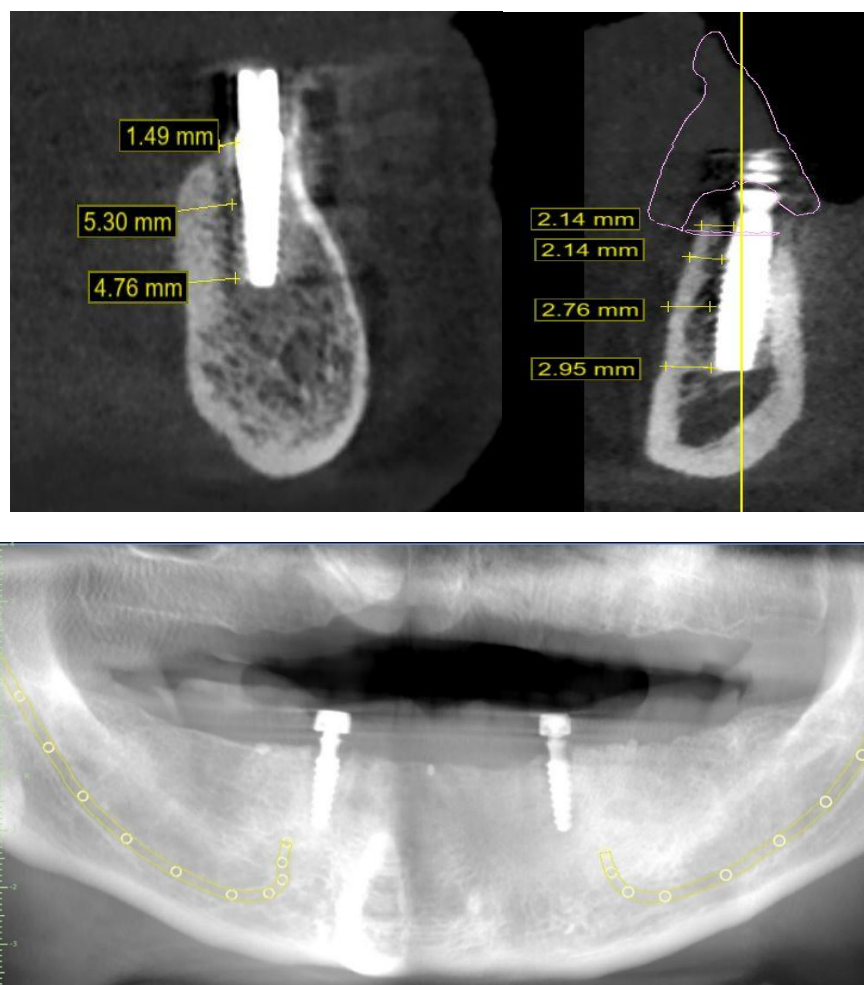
CBCT to determine the level of the bone resorption.
